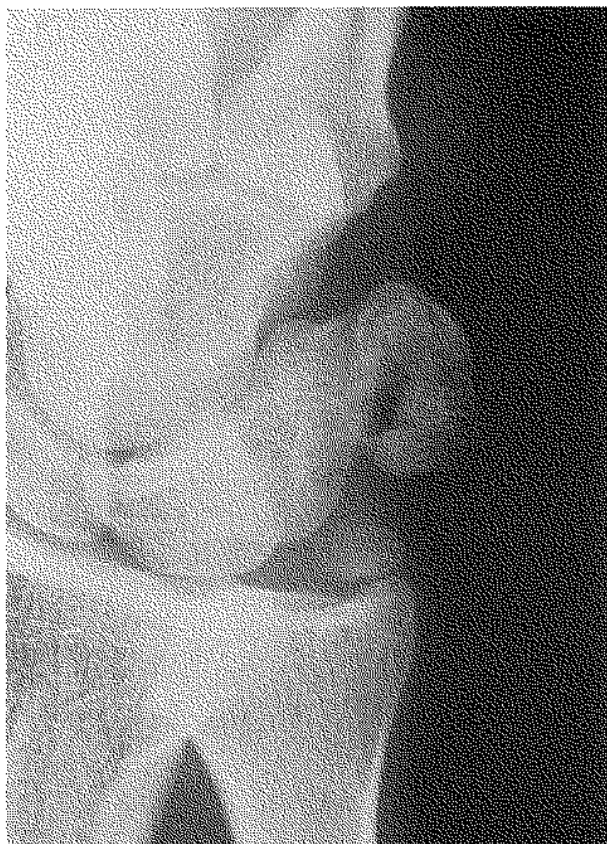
Fracture of the pisiform seen on oblique radiograph.
